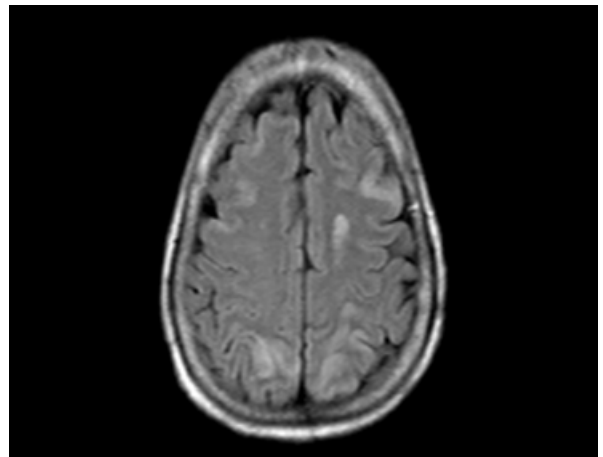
MRI Brain(T2 FLAIR) Showing Water Shed Infarcts
